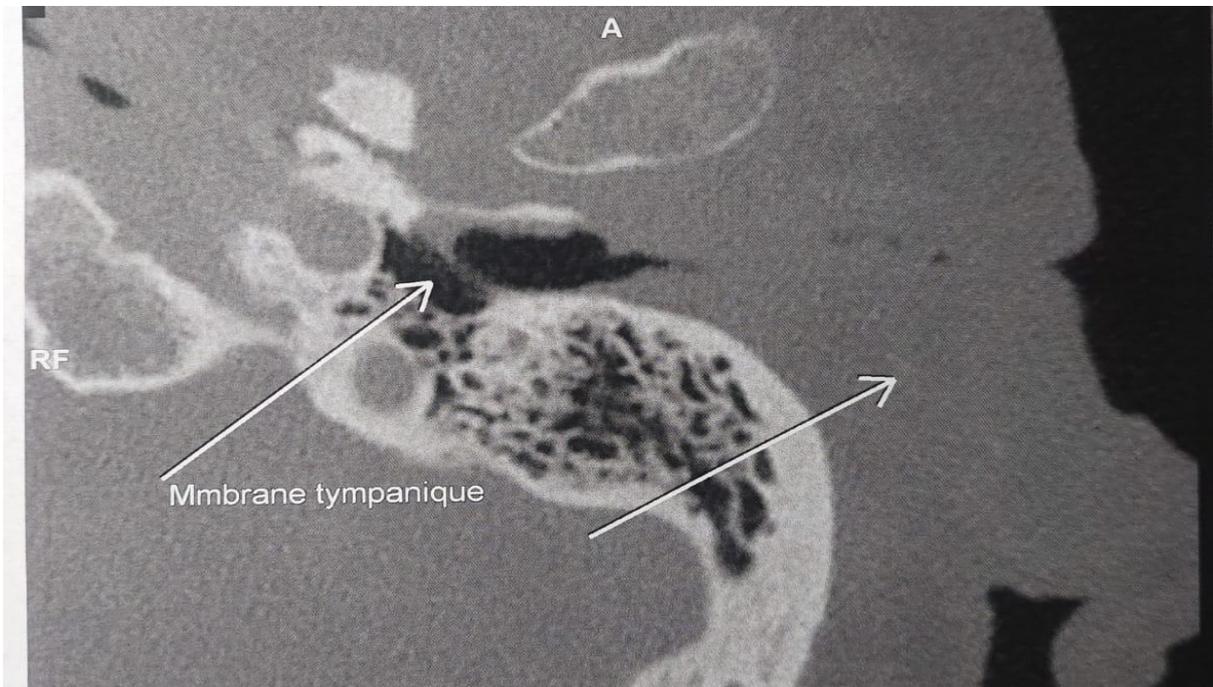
CT scan of the left petrous bone in horizontal section showing the tumor without bone lysis of the external auditory canal.
